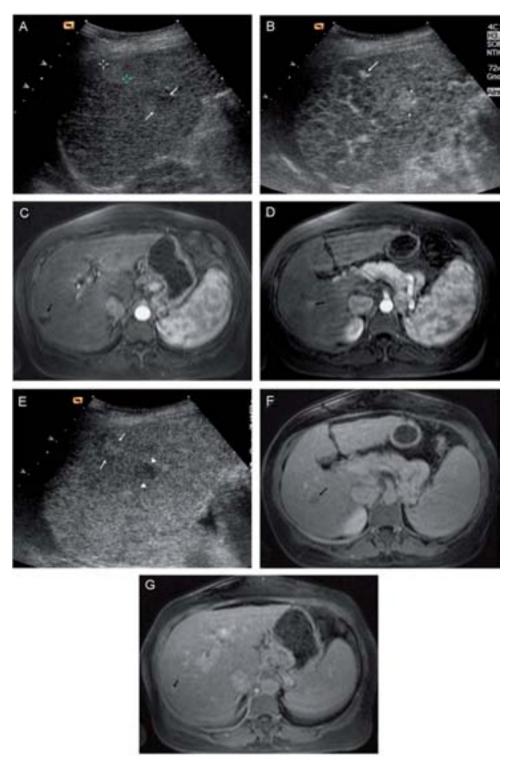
Simultaneous detection of two lesions: a benign lesion (hemangioma) subcapsular and a malignant lesion (HCC) in a patient with cirrhosis. The lesions were studied using CEUS and MRI. A) In the baseline ultrasound, two juxtaposed lesions are observed in the right liver lobe; one of them is lightly echogenic and more subcapsular (cursors), and the other is more hypoechoic and is located deeper (arrows). B) In the arterial phase of CEUS, the administration of a contrast agent allows for the observation of two different uptakes. In the subcapsular lesion, peripheral nodular uptake appears (arrow), whereas in the profound lesion, complete uptake is observed (tip of arrow). C) In the arterial phase of the MRI, the same peripheral nodular uptake is observed in the subcapsular lesion (arrow). D) In the arterial phase of the MRI, complete uptake of the profound lesion is confirmed (arrow). E) In the delayed venous phase of CEUS, the subcapsular lesion stays iso-hyperechogenic with respect to the rest of the parenchyma (arrows), while the profound lesion is also observed (arrow). G) In the delayed venous phase of the MRI, the subcapsular lesion remains isointense compared to the surrounding parenchyma.
